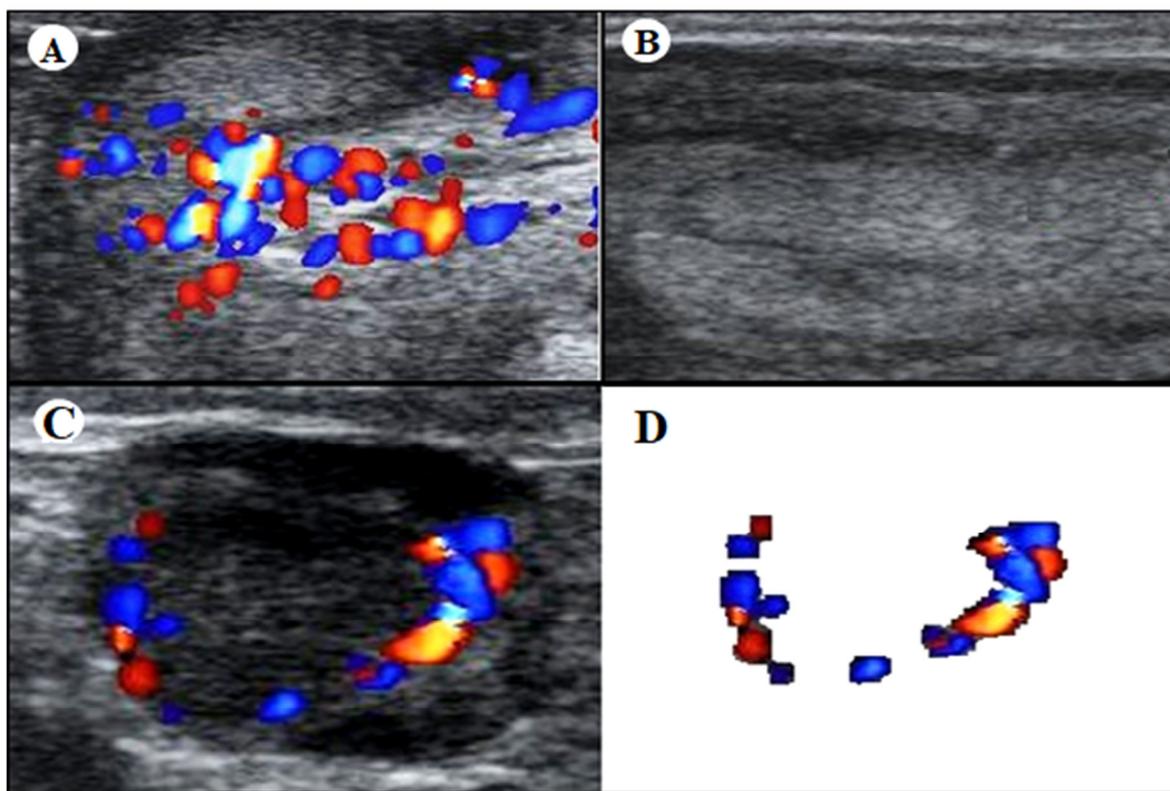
Uterine ultrasonography showing blood flow in Color Doppler mode (A) and the same structure in B-mode (B). The image of the CL in Color Doppler mode (C) and the same image edited by Adobe Photoshop CS5 for color pixels count (D).
